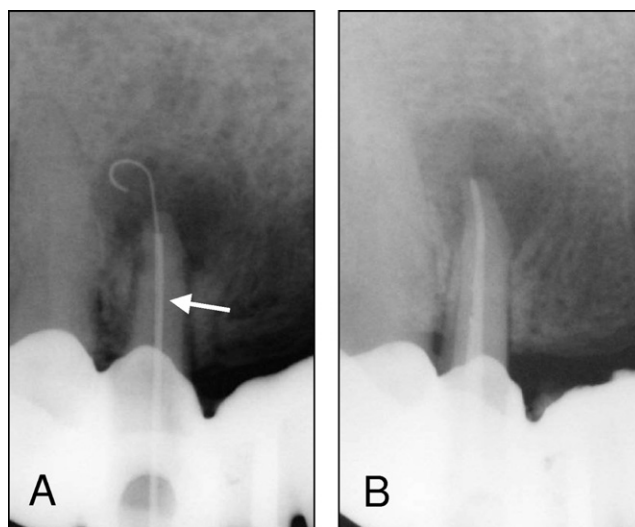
The Apexum NiTi Ablator in a periapical lesion. (A) The NiTi Apexum Ablator fully extruded from its sheath (arrow) and into the periapical lesion. (B) Root canal filling performed immediately after the Apexum procedure.
